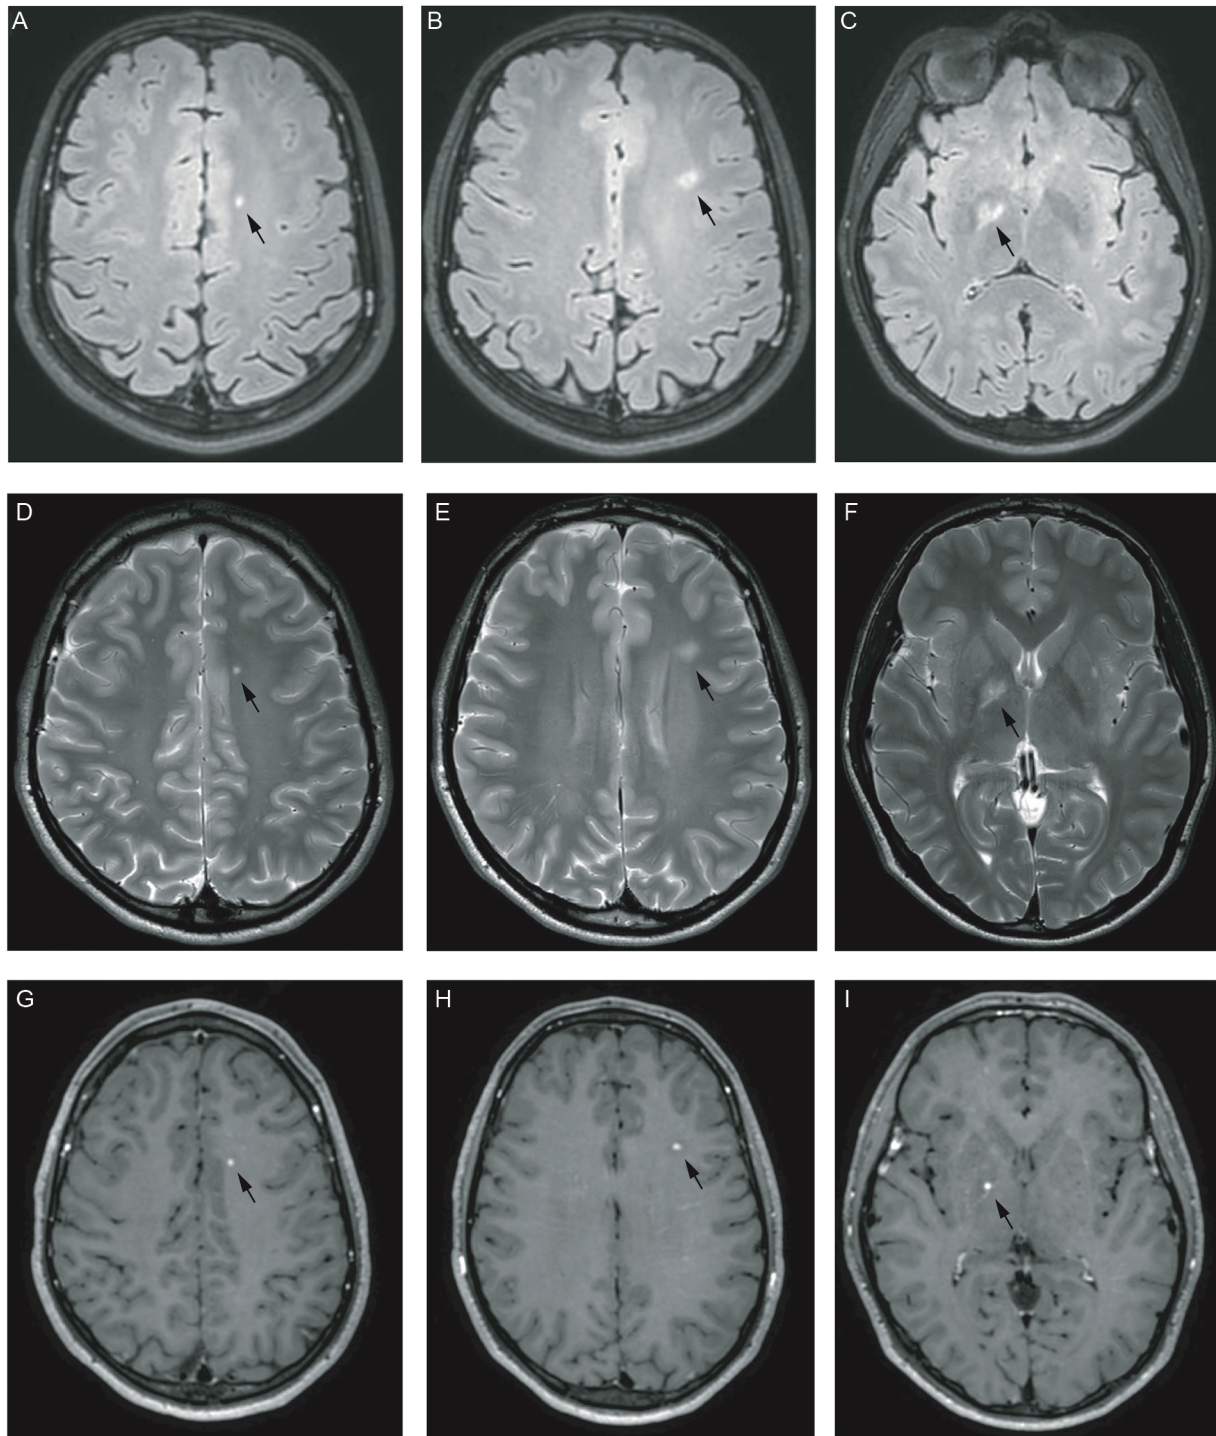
Magnetic resonance imaging patient 1. Axial fluid-attenuated inversion recovery imaging (A–C), T2-weighted imaging (D–F), and gadolinium-enhanced imaging (G–I) of patient 1 upon diagnosis showed several patchy as well as punctate bihemispheric supratentorial signal altered lesions in basal ganglia and white matter with gadolinium enhancement. Arrows point to lesions.
